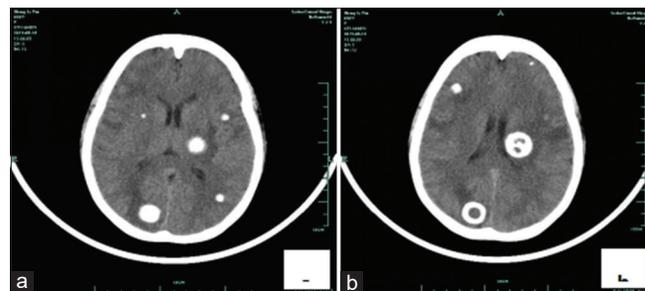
Computed tomography scan revealing multiple calcification metastases with edema (a and b)
